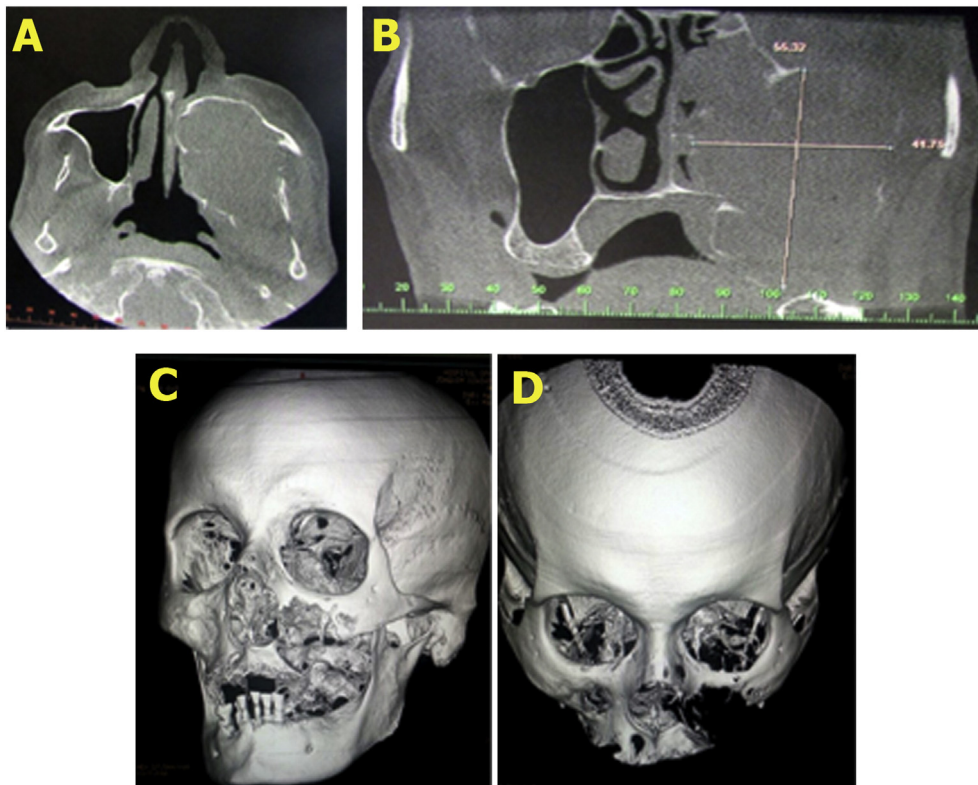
Initial exams. Axial and coronal CBCT scans showing bone destruction of part of the left wall of the nasal cavity and compromise of the floor of the left orbit; below, three-dimensional reconstruction of the case showing the involvement of the facial bone.
